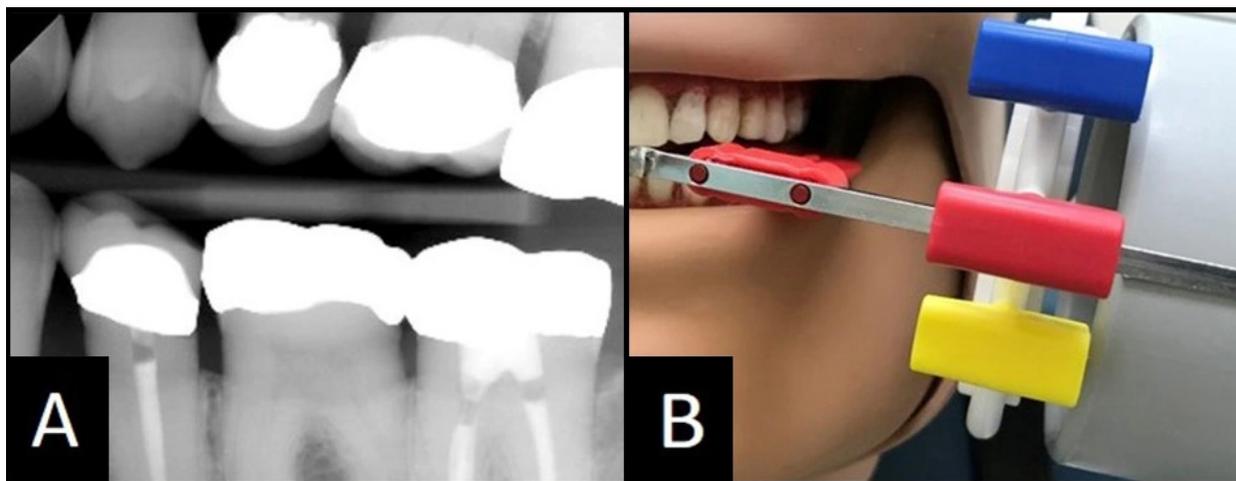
Bitewing image did not capture Maxillary margins or bone.
